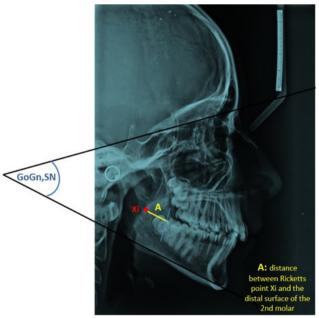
Measurements performed on lateral cephalometric radiographs.
